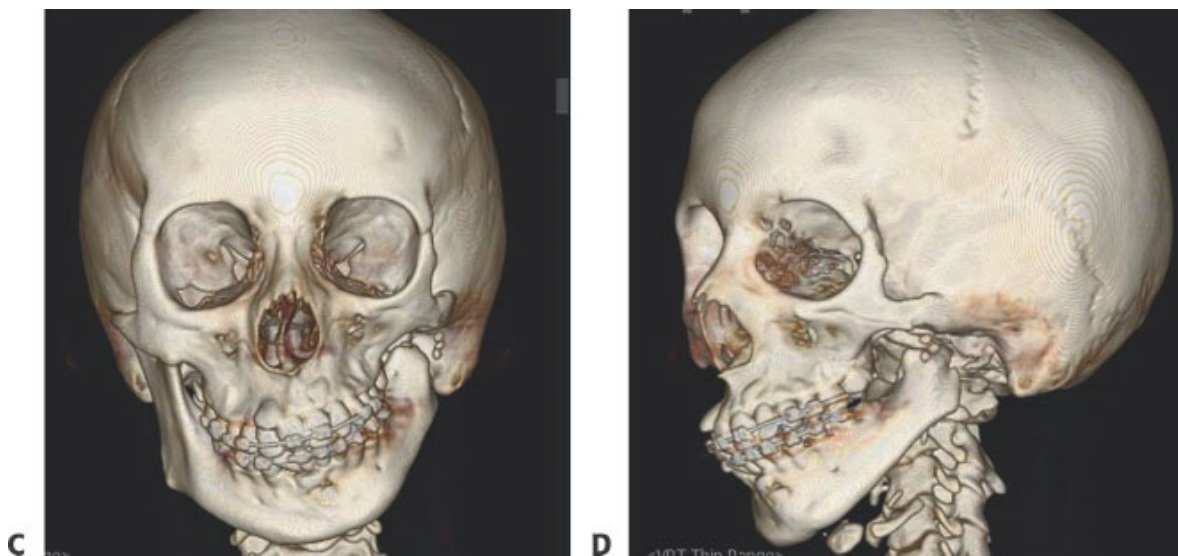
• Soft tissue (A), bone 3D CT scan (B), and AP (C) and oblique (D) bone window 3D CT scans demonstrating a shortened vertical ramus (type IIB) mandible with significant distance between the malshaped condyle and the proposed glenoid fossa location.
